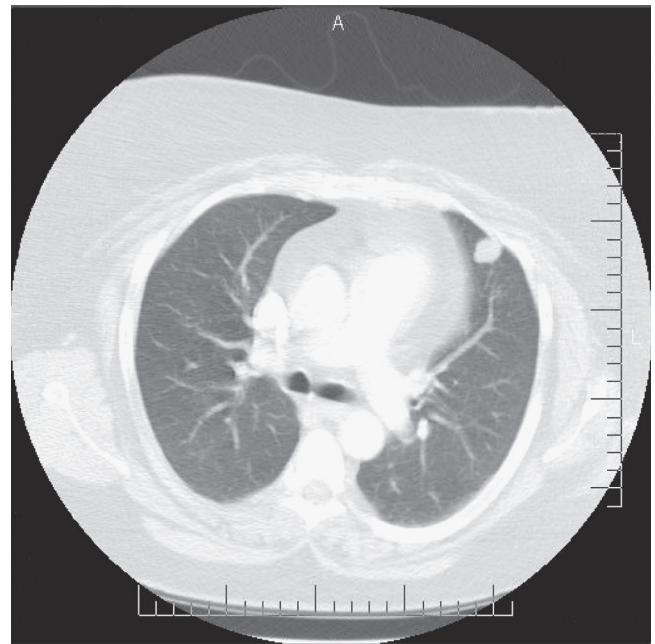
■ CT scan of the chest showing a chondroid hamartoma measuring 1.4×1.7 cm in the inferior lingula of the left lung. The patient was a 49-year-old woman with a normal PET scan. Because her clinical presentation was suggestive of malignant disease, a left upper lobe wedge resection was performed. Ninety percent of hamartomas are located in the periphery, and they account for about 4% of all solitary lung nodules.
